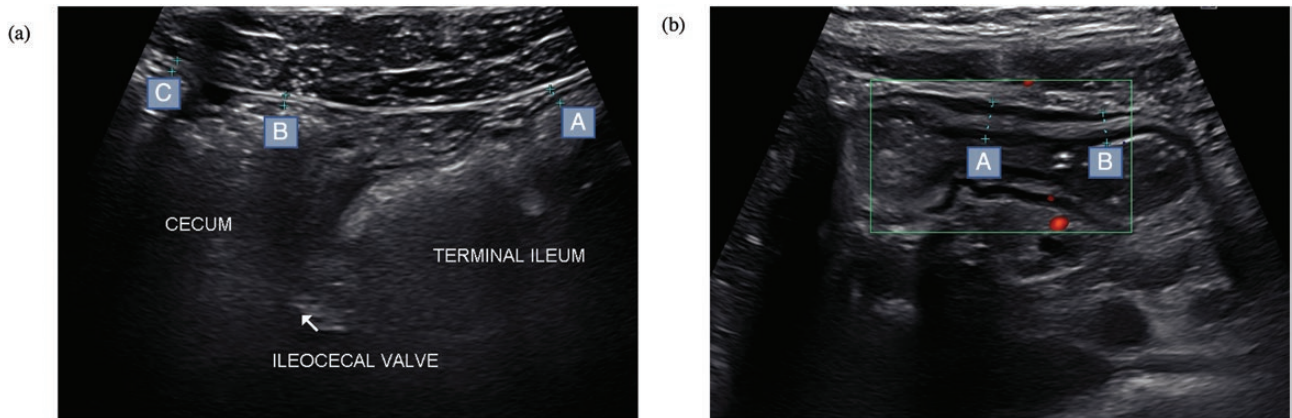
Intestinal ultrasound images demonstrating the use of Doppler ultrasound and other adjunct measures of inflammation using the Canon i700 machine. (A) Normal terminal ileum, cecum, and ileocecal valve from Crohn's disease patient in remission. Points A, B, and C measure the bowel wall thickness at 0.23 cm, 0.13 cm, and 0.16 cm, respectively. (B) Inflamed terminal ileum in a Crohn's disease patient in an active flare. Points A and B measure at 0.53 cm and 0.43 cm, respectively. There is minimal disruption of mural stratification and active blood flow in the area.
